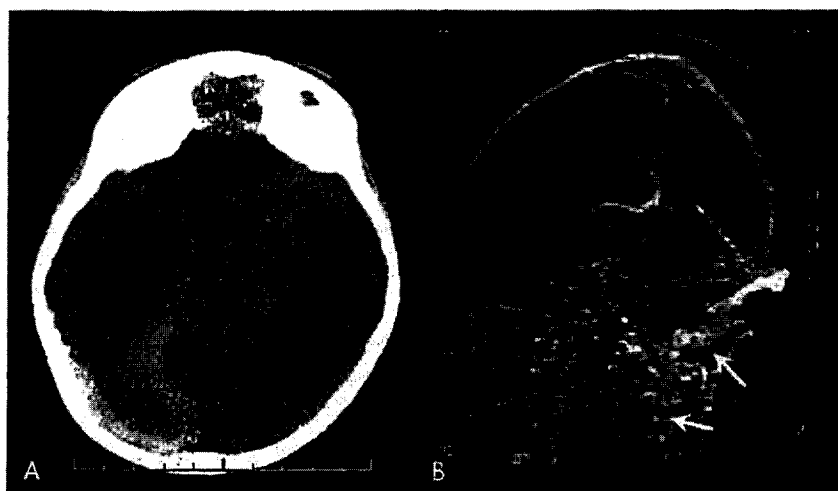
Images obtained from a 19-month-old boy who had 1 week of febrile illness (treated with antibiotics), followed by ALTE with RHs. A, Computed tomographic image shows high-density hemorrhages (or thromboses) along the right tentorium and dural venous sinuses. B, Magnetic resonance imaging with MRV shows irregular flow gaps with incomplete opacification of the right-side internal jugular vein and sigmoid sinus. Other flow gaps were demonstrated within the superior sagittal and straight sinuses, along with multiple venous collaterals (diagnosis, DVST).
